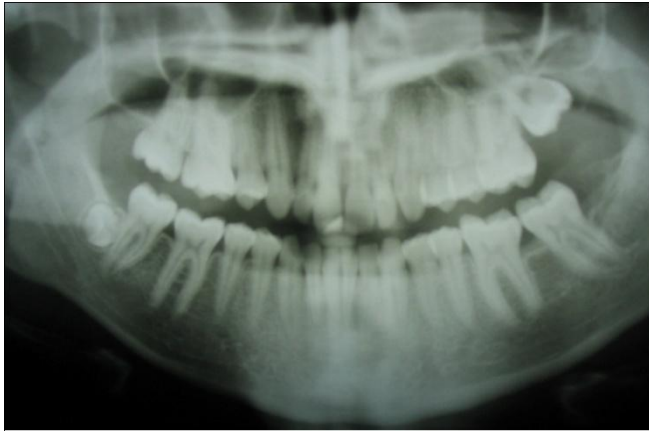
Orthopantomogram eighteen month post operatively
